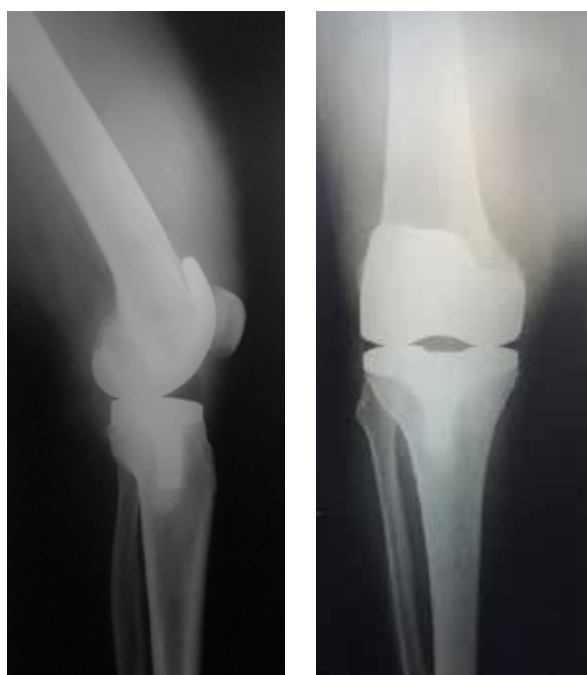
Radiographs of Patient S., 55 years old, following primary total cemented right knee arthroplasty performed under computed navigation system control
